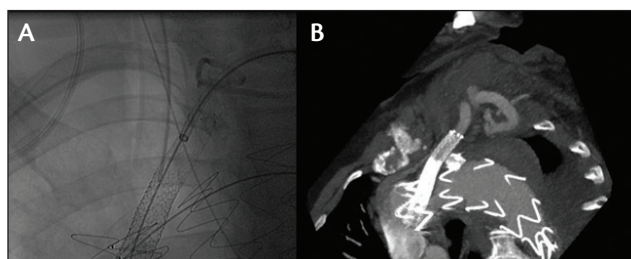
Intraoperative angiography of a patient with implantation of a Zenith Alpha endograft (Cook Medical) and a chimney endograft (Advanta, Maquet) for the LCCA (A). Maximal intensity projection reconstruction of a CTA from the same patient (B).
